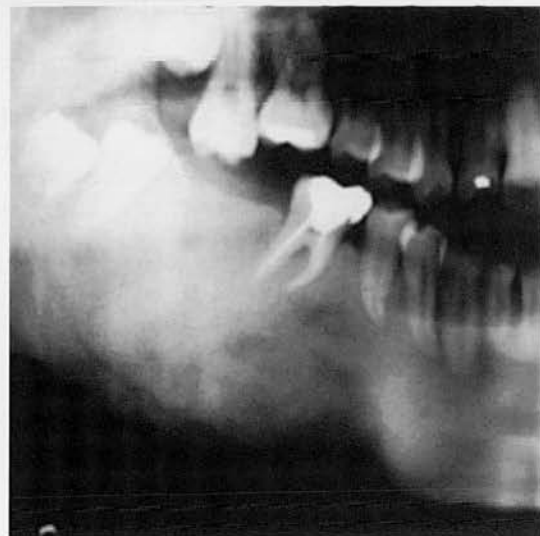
(Case 2) Part of a panoramic radiograph displaying marked vertical expansion of the right side of the body of the mandible. The inferior dental canal has been displaced markedly downwards. Although the lesion exhibits a predominantly 'ground glass' pattern there are some linear trabeculae below the inferior dental canal and the region below the premolars is radiolucent. The lower border of the mandible is completely absent from the angle almost to the midline. The second and third molars have been displaced backward into the ramus
